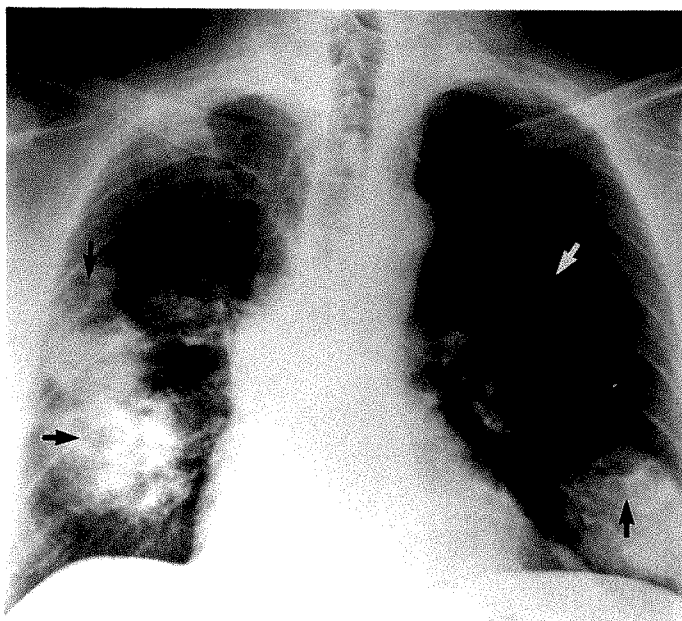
Chest radiograph shows multiple cavitary nodules (arrows) in both lungs. Some nodules have become confluent. Cavities have thick nodular walls and several contain air/fluid levels.
